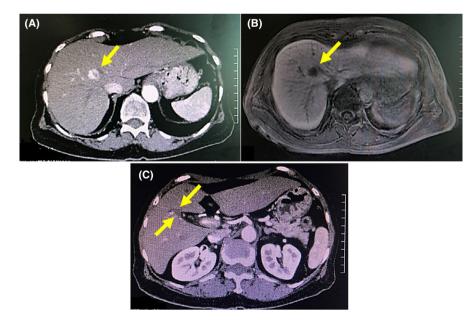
A, Abdominal contrast-enhanced computed tomographic scan in early phase. Liver morphology is almost normal with no splenomegaly. A high-low pattern lesion with a diameter of 18 mm was observed in segment 8 of the liver (*arrow*); therefore, hepatocellular carcinoma (HCC) recurrence was diagnosed. B, Abdominal contrast-enhanced magnetic resonance imaging scan in hepatobiliary phase. The hepatic morphology was almost normal. A high-low pattern was observed in dynamic imaging with a diameter of 18 mm in segment 8 of the liver, and a neoplastic lesion that was a contrast-deficient image in the hepatocyte contrast phase was recognized (*arrow*), confirming HCC recurrence. C, Abdominal contrast-enhanced computed tomographic scan in early phase. The RFA treatment scar of segment 4 performed at the previous hospital (*arrow*) was not in contact with the new lesion of segment 8
